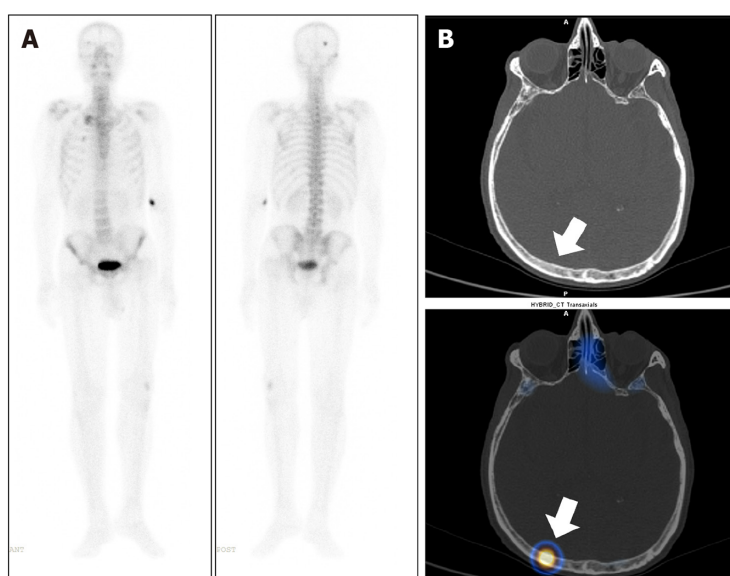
A 76-year-old male, with a newly diagnosed case of carcinoma of the prostate underwent whole body bone scintigraphy. A: ^{99m}Tc methylene diphosphonate Whole body planar images show solitary focal area of increased tracer uptake involving skull bone on the right side; B: Axial computed tomography (CT) and fused single photon emission computed tomography-CT images show tracer localization to the right parietal bone (arrow) with no significant CT abnormality to suggest of metastatic disease involvement. The lesion was thus considered indeterminate.
